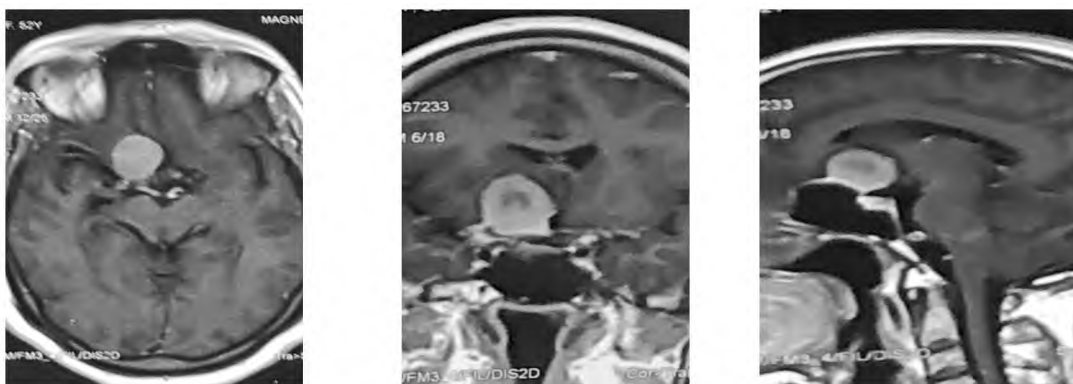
Pre operative MRI with contrast.
